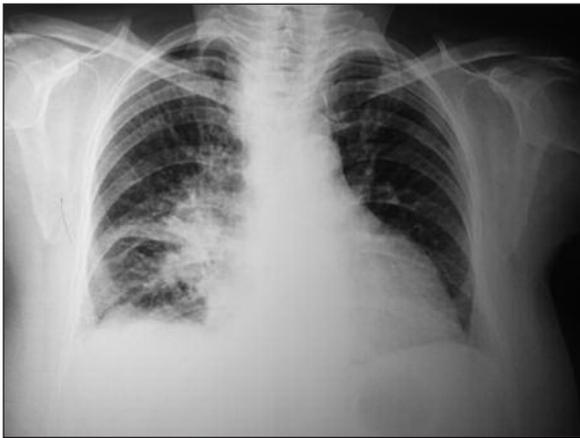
Right hilar enlargement observed on chest roentgenogram.
